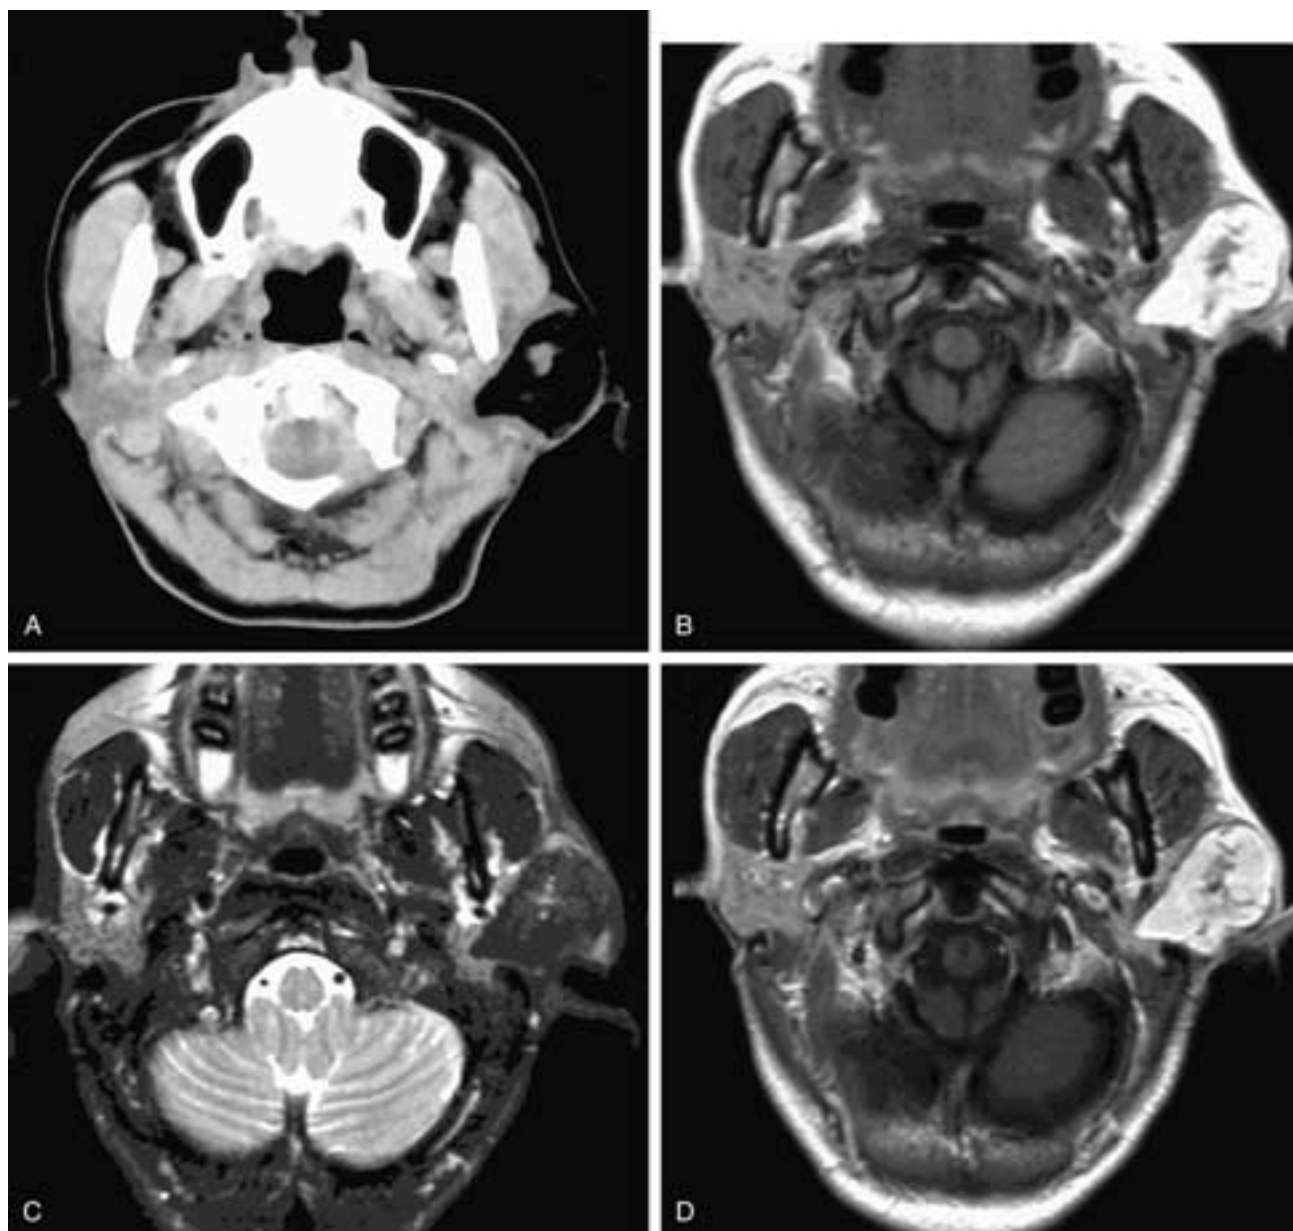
Axial CT scan (A) shows a fat attenuation mass in the left parotid gland and the adjacent soft tissues. Axial T1-weighted (B), T2-weighted (C), and T1-weighted, fat-suppressed, contrast-enhanced (D) MR images show a mass with a high T1-weighted and a low T2-weighted signal intensity. There is faint enhancement. Within the mass are structures of low T1-weighted and high T2-weighted signal intensity. These structures do not enhance. This patient had sclerosing adenosis.
